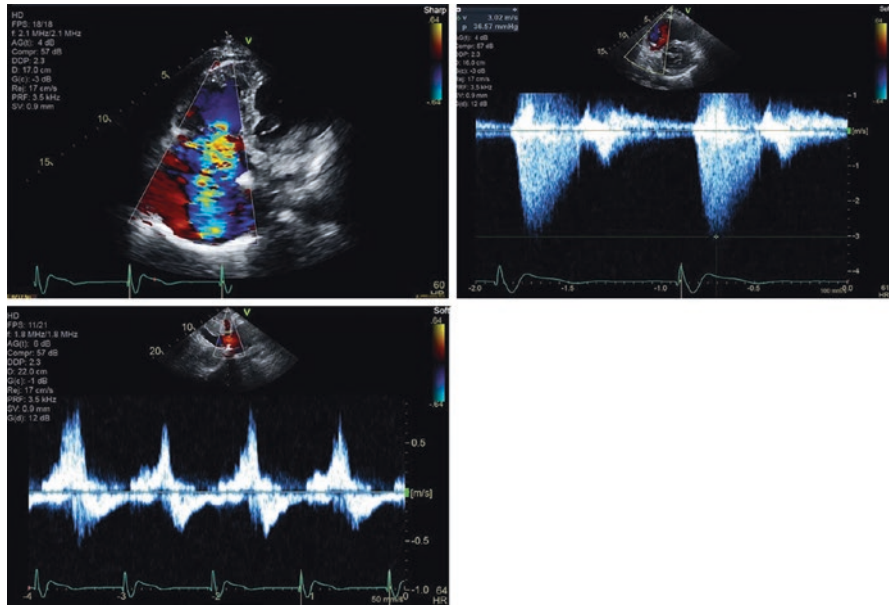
Features of severe TR. Upper Left: Color Doppler jet area >10 cm² (Video 5.4). Upper Right: Triangular continuous-wave tricuspid regurgitation signal. Bottom: Systolic reversal of the hepatic vein flow in the subcostal window
